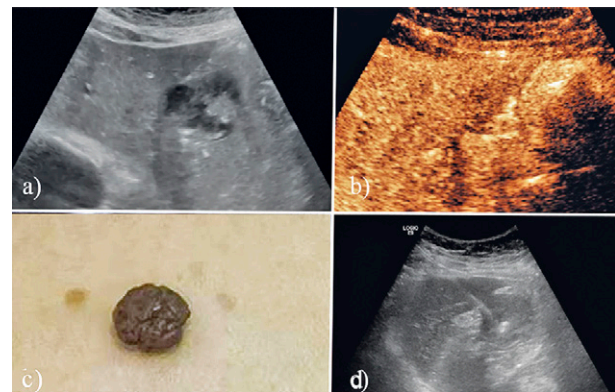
a) A solid hypoechoic mass on the lesser curvature of the gastric body, originating from the gastric muscularis propria, protrudes outward from the gastric lumen. The internal echoes are heterogeneous, with the surrounding gastric wall layers remaining distinctly defined; b) CEUS reveals a gastric lesion with uneven hypoenhancement. No perfusion defects are observed within the lesion, while enhancement is noted around its periphery; c) Brownish roundish nodule on the left anterior chest wall, elevated above the skin surface, cauliflower-like, about 2 cm in diameter; d) Under ultrasound guidance, a percutaneous biopsy of the gastric lesion, passing through a portion of the liver was performed.
